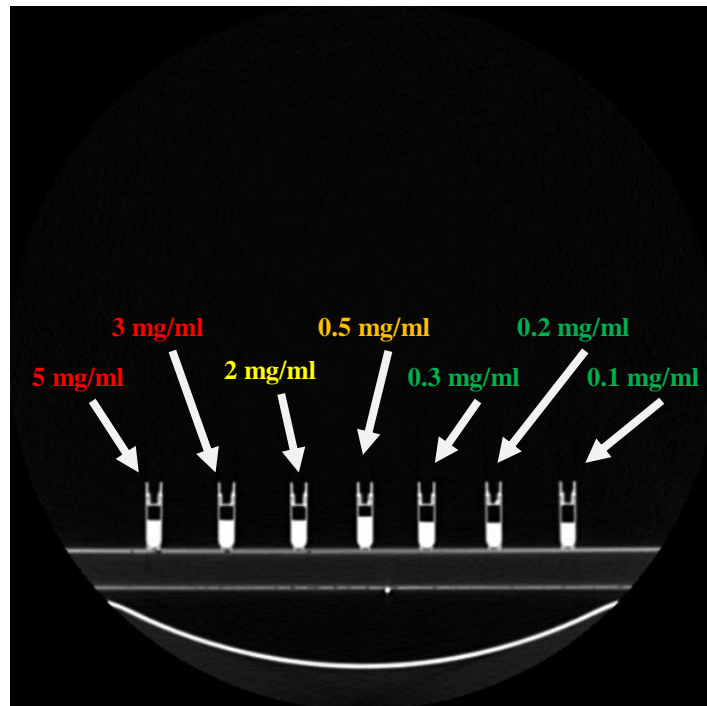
CT scan of commercial particles with different concentrations
